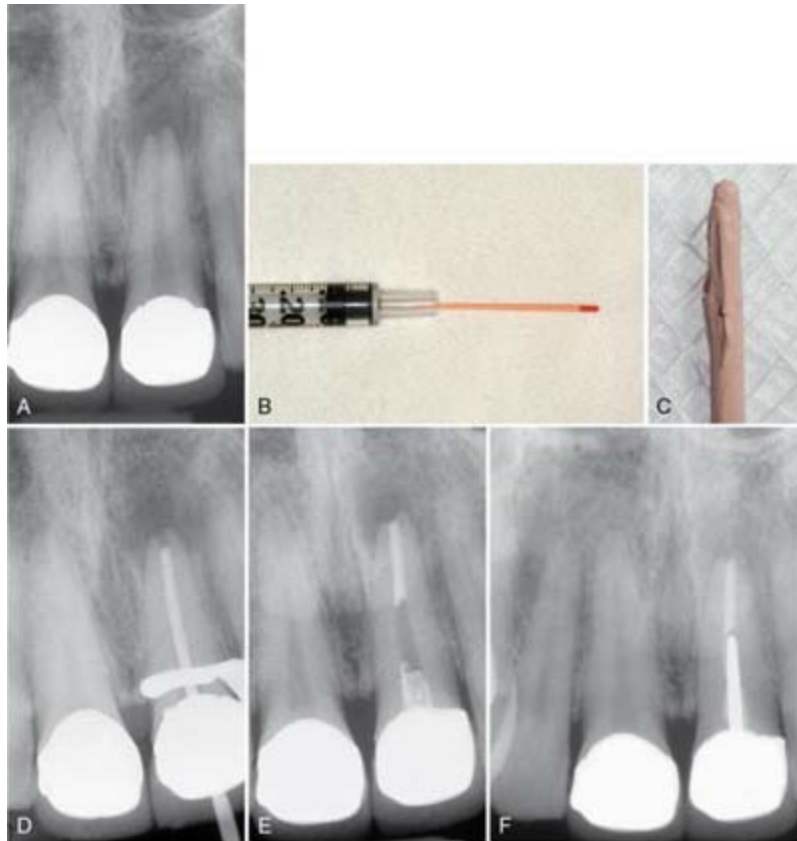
Apical root resorption often results in an open apex requiring fabrication of a custom cone. A, Pretreatment radiograph of a maxillary left central incisor with pulp necrosis and chronic apical periodontitis. Apical root resorption is present. B, In fabricating a custom master cone, a GP point is fit several millimeters short before softening in solvent and tamping into place. C, Softening the apical 2 to 3 mm in chloroform that has been placed in a tuberculin syringe. D, The completed custom cone represents an impression of the apical portion of the RCS. E, The posttreatment radiograph with post space prepared. F, A 1-year follow-up radiograph demonstrating osseous regeneration.
